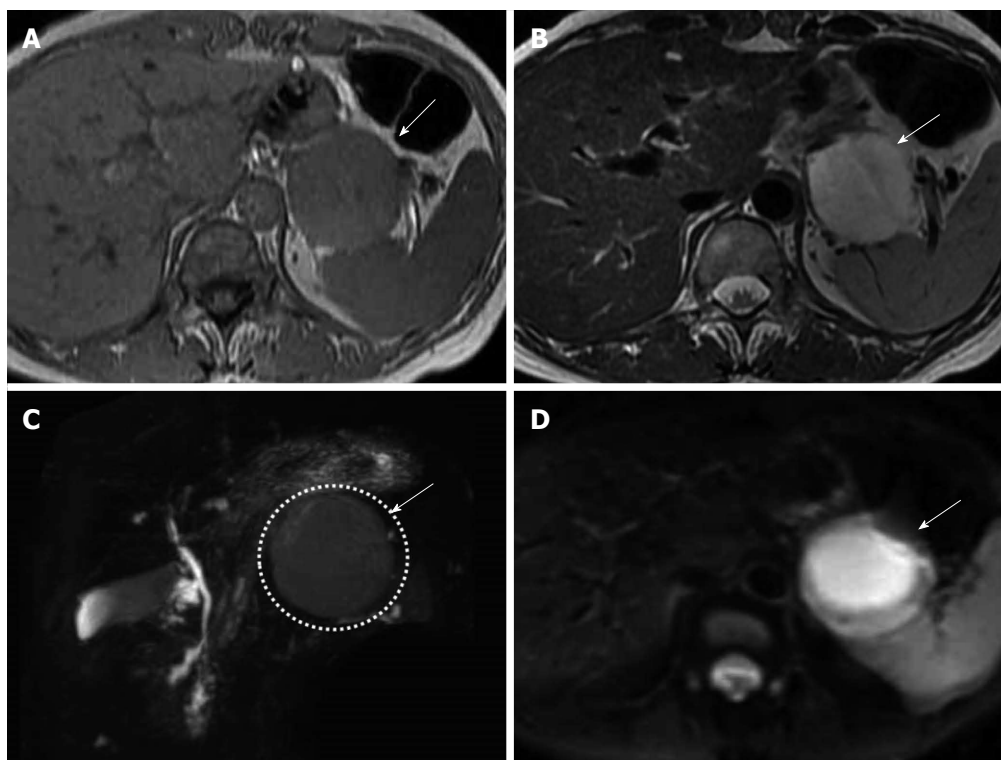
Findings of patient #2. A: Findings of T1-weighted imaging on magnetic resonance imaging (MRI). T1-weighted imaging of patient showed a higher intensity than free water (arrow); B: Findings of T2-weighted imaging on MRI. T2-weighted imaging of patient showed a lower intensity than free water (arrow); C: Findings of magnetic resonance cholangiopancreatography (MRCP). MRCP of patient showed a lower intensity than free water (arrow); D: Findings of diffusion-weighted imaging on MRI (arrow). Diffusion-weighted imaging of three patients showed a higher intensity than free water. The cystic lesions showed high intense signal in the central part and iso-intense in the periphery.
